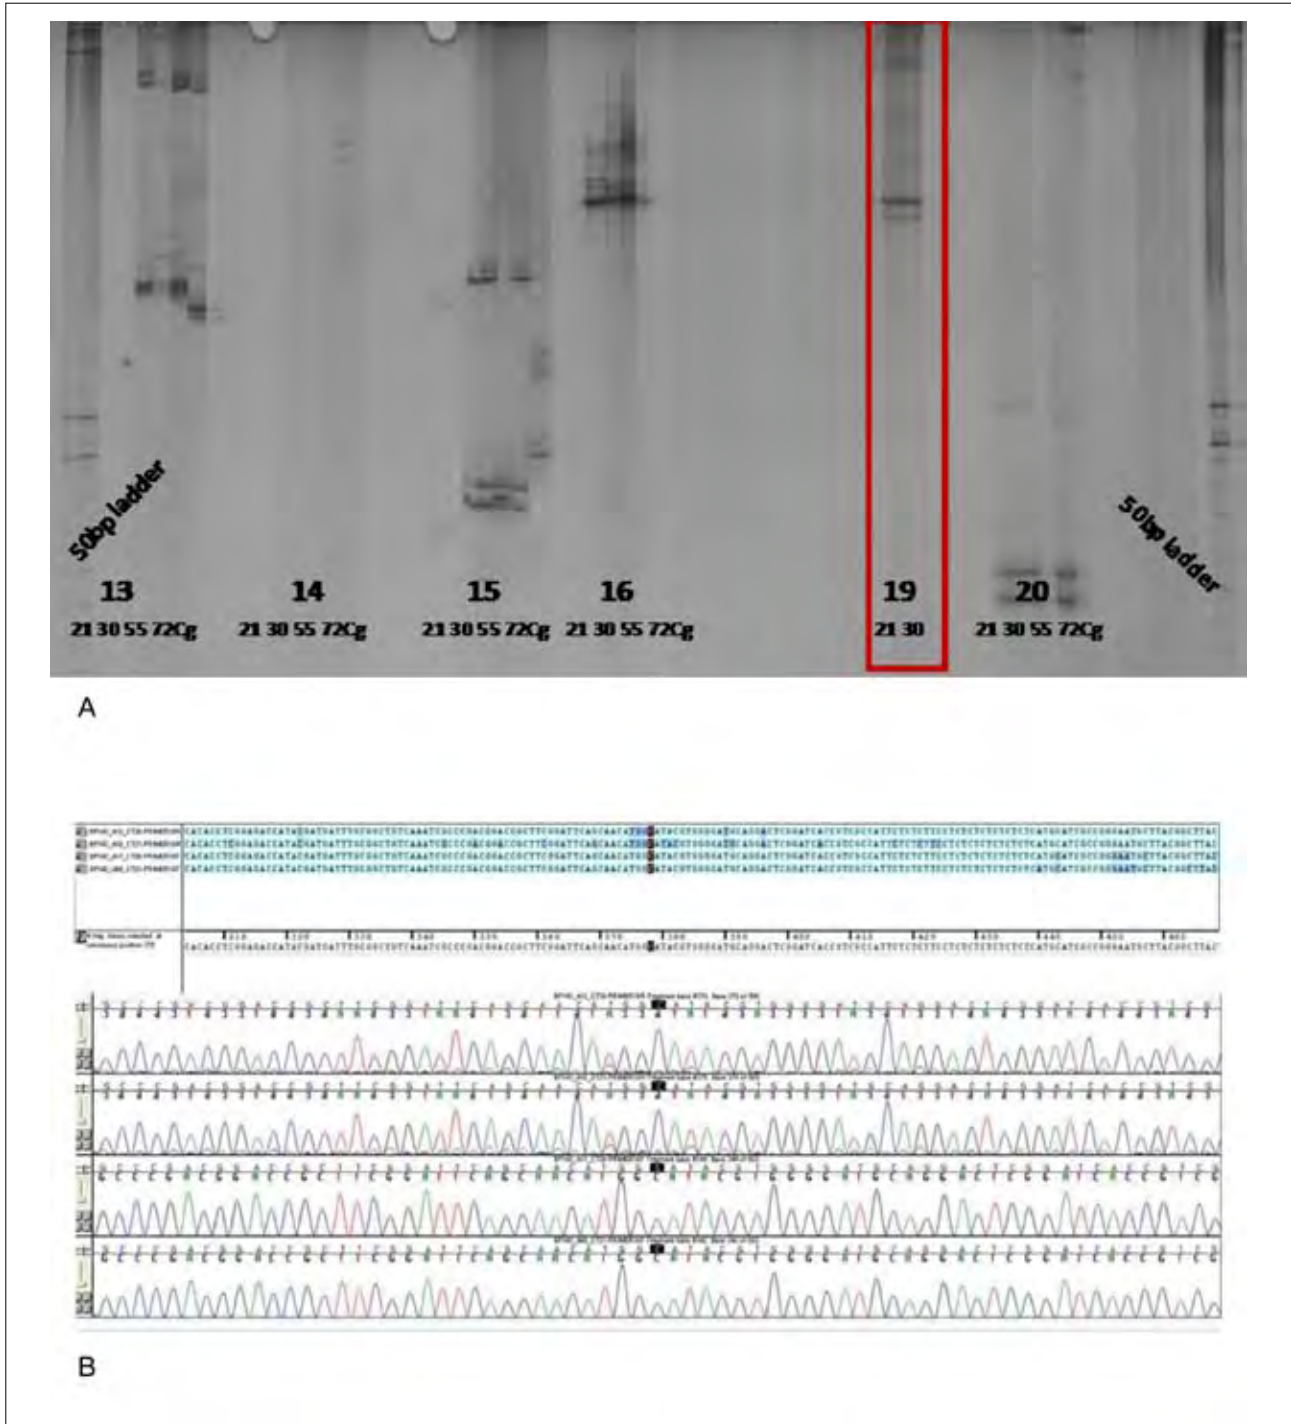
Validation of SSCP Gels with Sanger Sequencing. A. SSCP Gel with EST Primers 13-20 on CT-21, CT-30, CT-55, GT-72 and CG. B. Sequence Alignment and Chromatograph for Primer 19 on CT-21 and CT-30.
